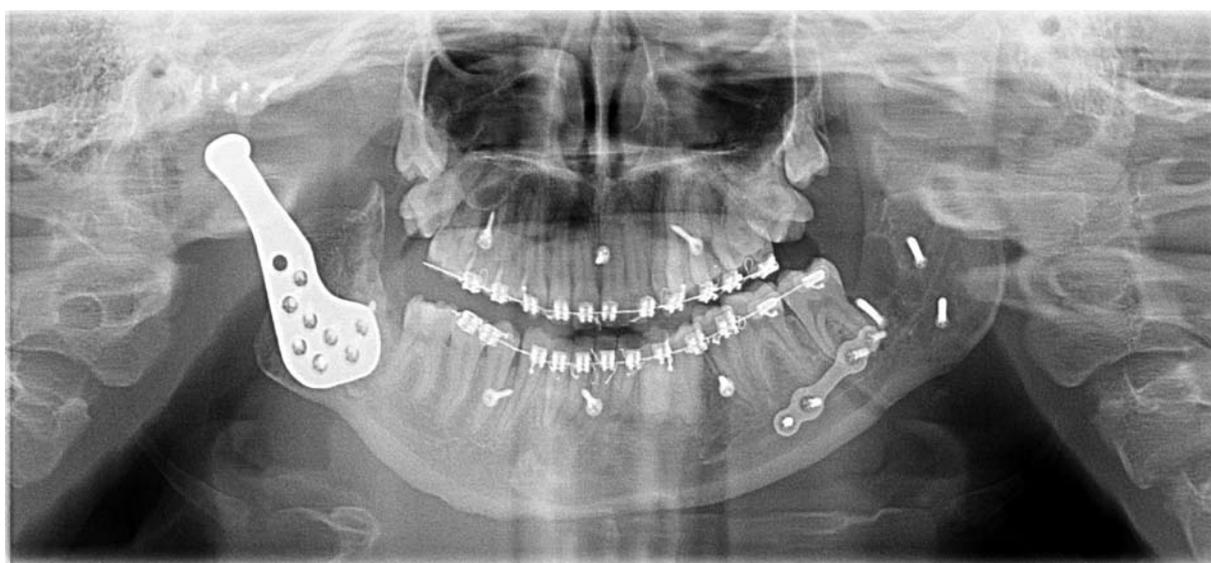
Panoramic X-ray after implantation of right artificial temporomandibular joint
